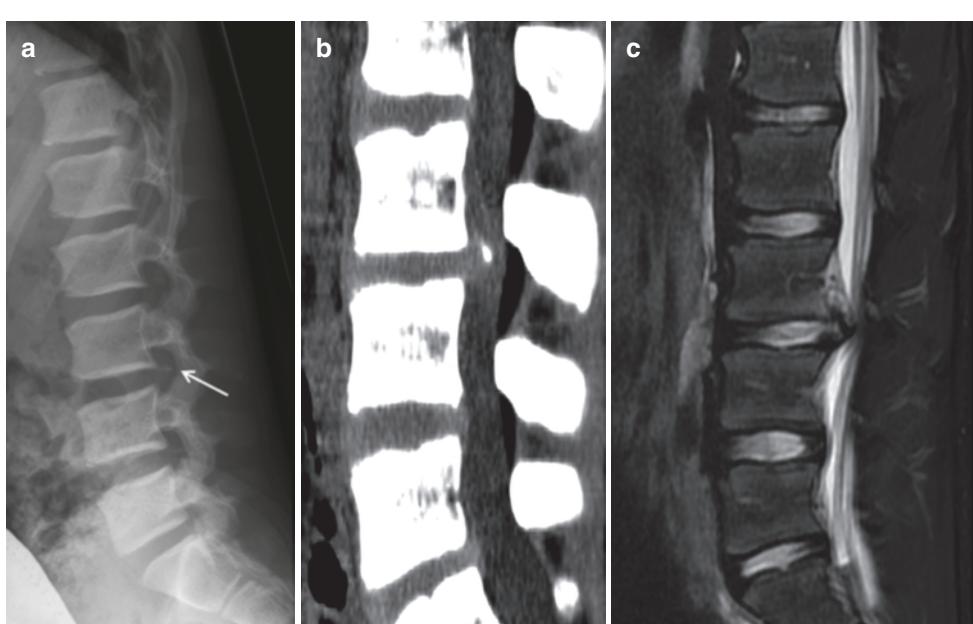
(a) Lateral radiograph of the lumbar spine of a 14-year-old boy with worsening lower back pain. There is a subtle bone density posterior to the inferior endplate of L3 (arrow). Note the normal non-fused ring apophysis
